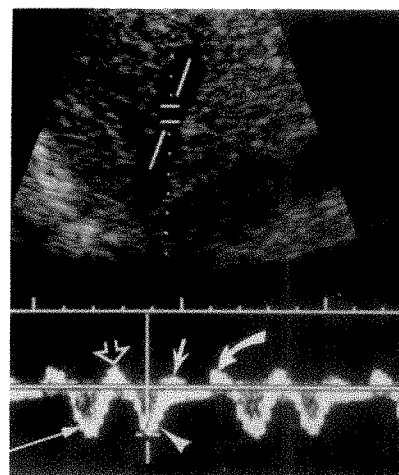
Normal hepatic vein duplex Doppler sonogram shows a c wave (curved arrow). Systolic wave (long straight arrow); v wave (open arrow); diastolic wave (arrowhead); a wave (short solid arrow).
